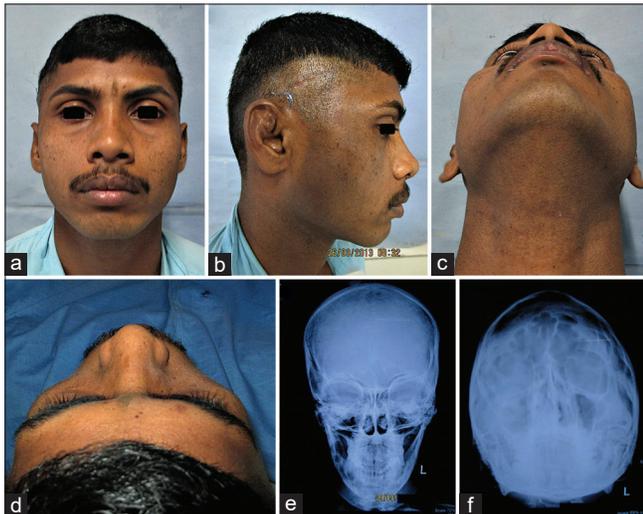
(Case 3) (a-d) Good postoperative healing with an excellent restoration of facial symmetry and esthetics. (e and f) Postoperative radiographs confirmed achievement of a symmetrical contour of the mid-third of the facial skeleton
